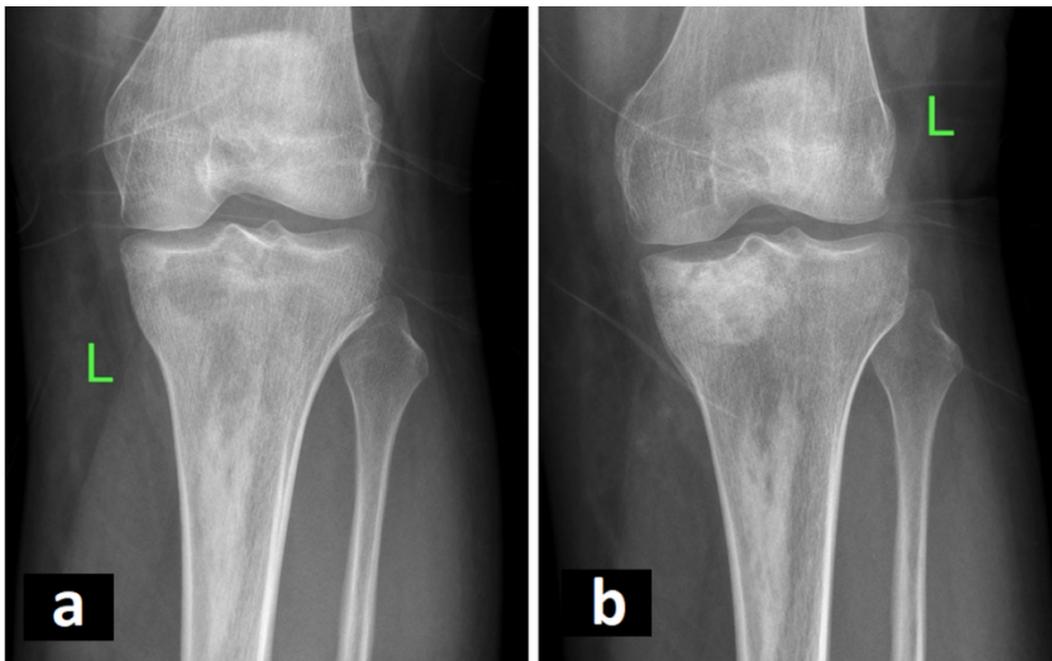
18-year-old male with chondroblastoma of the left proximal tibia treated by curettage and bone grafting (4a:preoperative radiography, 4b:postoperative radiography).
